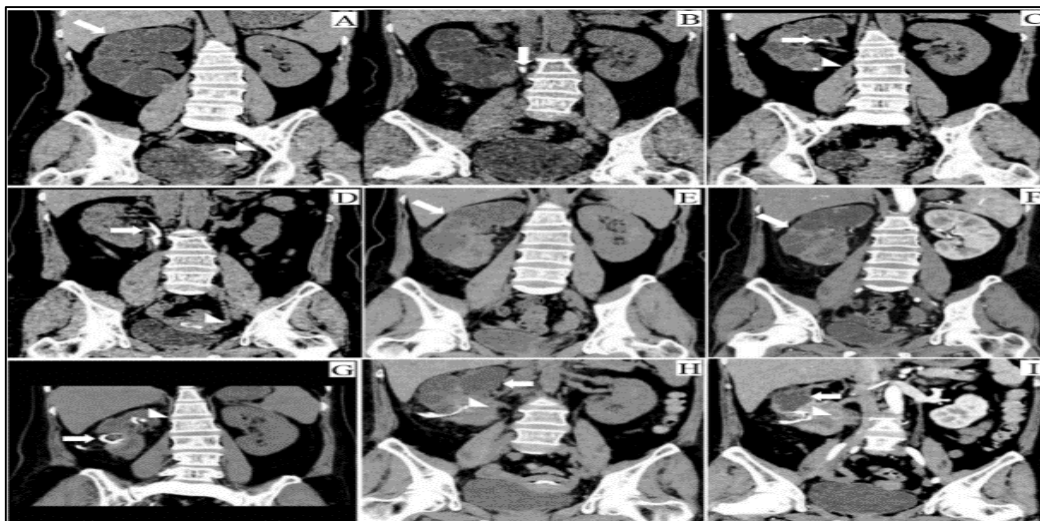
Axial CT of the right kidney
